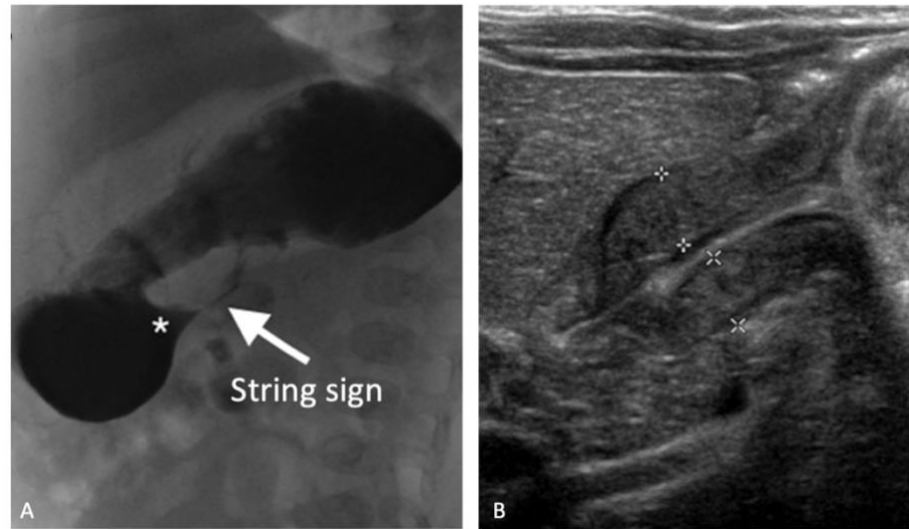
(A) Upper gastrointestinal contrast study demonstrates string sign in patient with hypertrophic pyloric stenosis. (B) Ultrasound finding: thickening of the pyloric musculature and elongation of pyloric outlet.³
